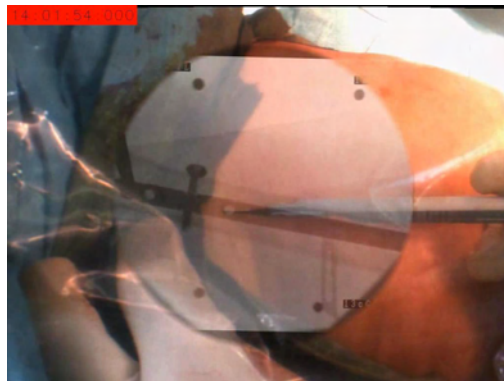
The entry point on the skin for the locking hole is identified using the live video co-registered by the X-ray image.
